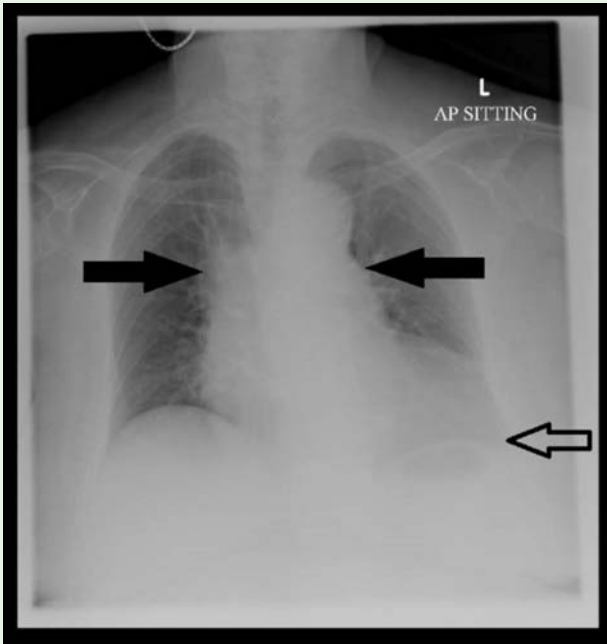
Chest x-ray showed a widened mediastinum (as indicated by the black arrows) with a left-sided pleural effusion (as indicated by the black-outline arrow).
